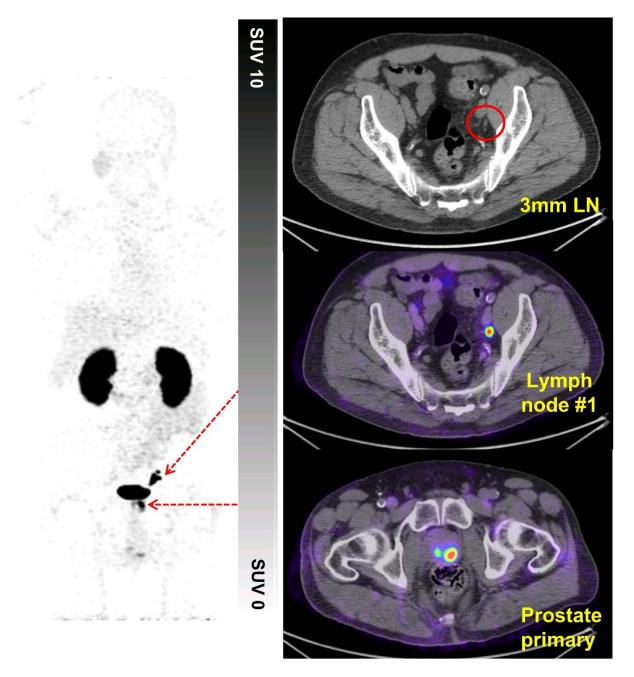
Patient with Gleason 4 + 5 = 9 prostate adenocarcinoma with high uptake in the primary prostate tumor and focal uptake in several left external iliac lymph nodes less than 5 mm in size (120 minute image shown). The patient proceeded to prostatectomy and pelvic nodal clearance. Pathologic staging demonstrated no nodal involvement (pN0 stage). Follow-up demonstrated persistently elevated and rising PSA, with repeat imaging at 6 months confirming presence and progression of baseline ⁶⁸Ga-THP-PSMA PET/CT findings. The pN0 staging is therefore interpreted as false negative due to sampling error.
